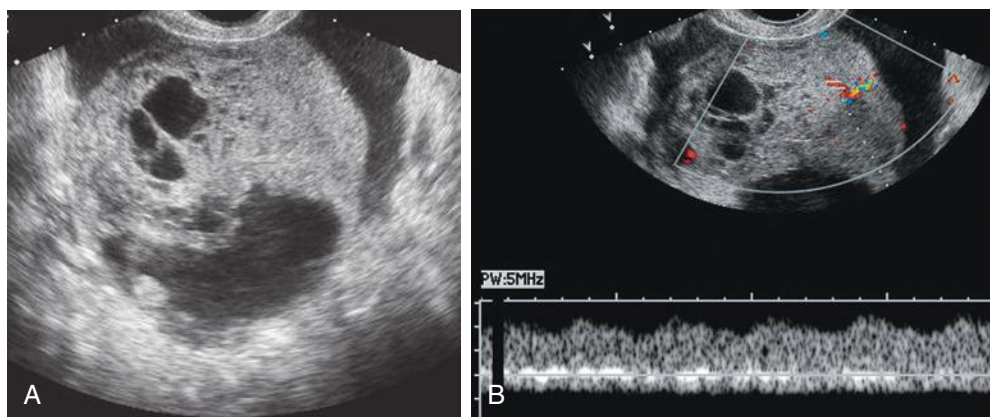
Clear cell cystadenocarcinoma of the ovary. A, Mixed cystic and solid mass with a relatively large solid component. B, Color and spectral Doppler imaging confirm flow within the solid component of the mass.
